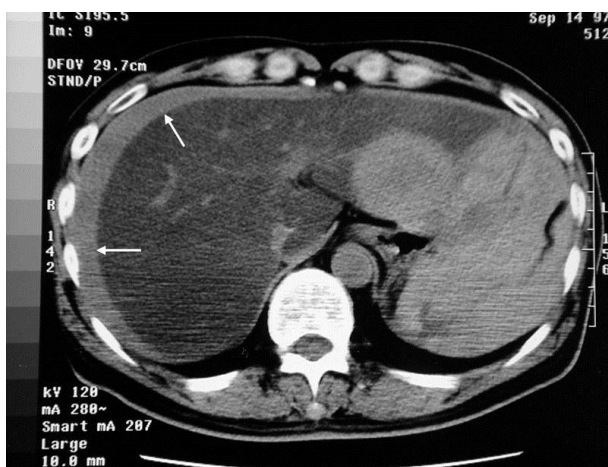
Precontrast CT image shows high-density fluid (arrows) surrounding perihepatic space due to hemoperitoneum. The liver parenchyma revealed lower density than the spleen, indicating fatty liver. A well-defined tumor at left-lobe liver is noted.
